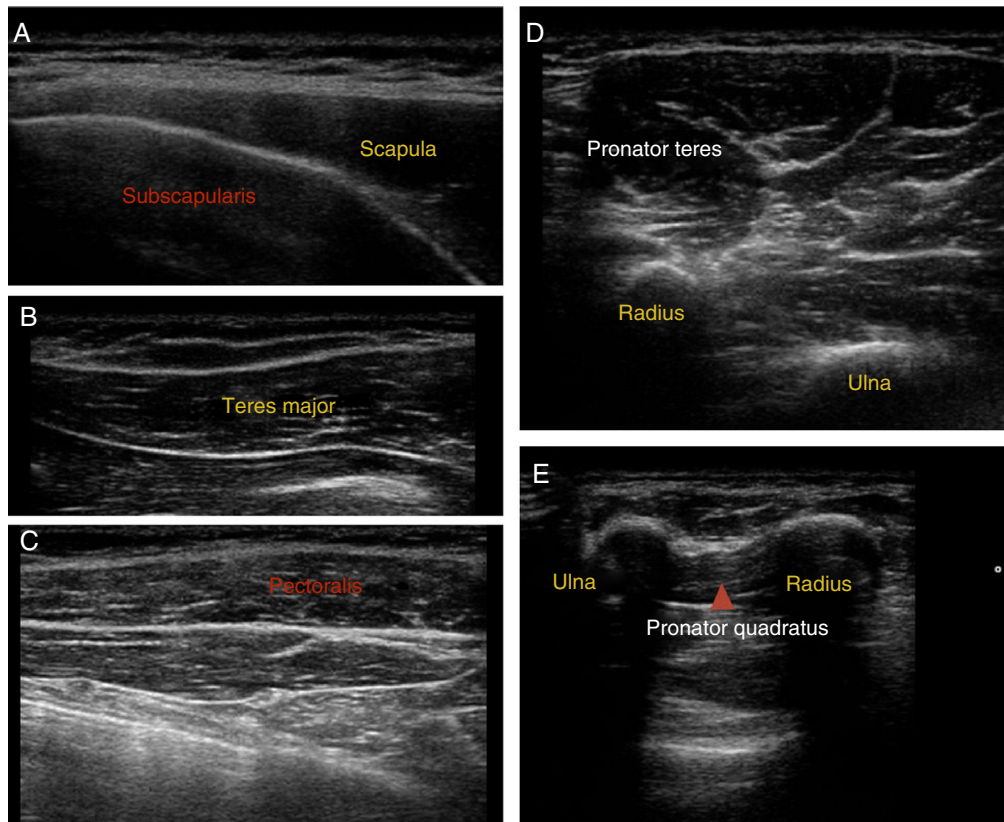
Ultrasound images of muscle localisation.
